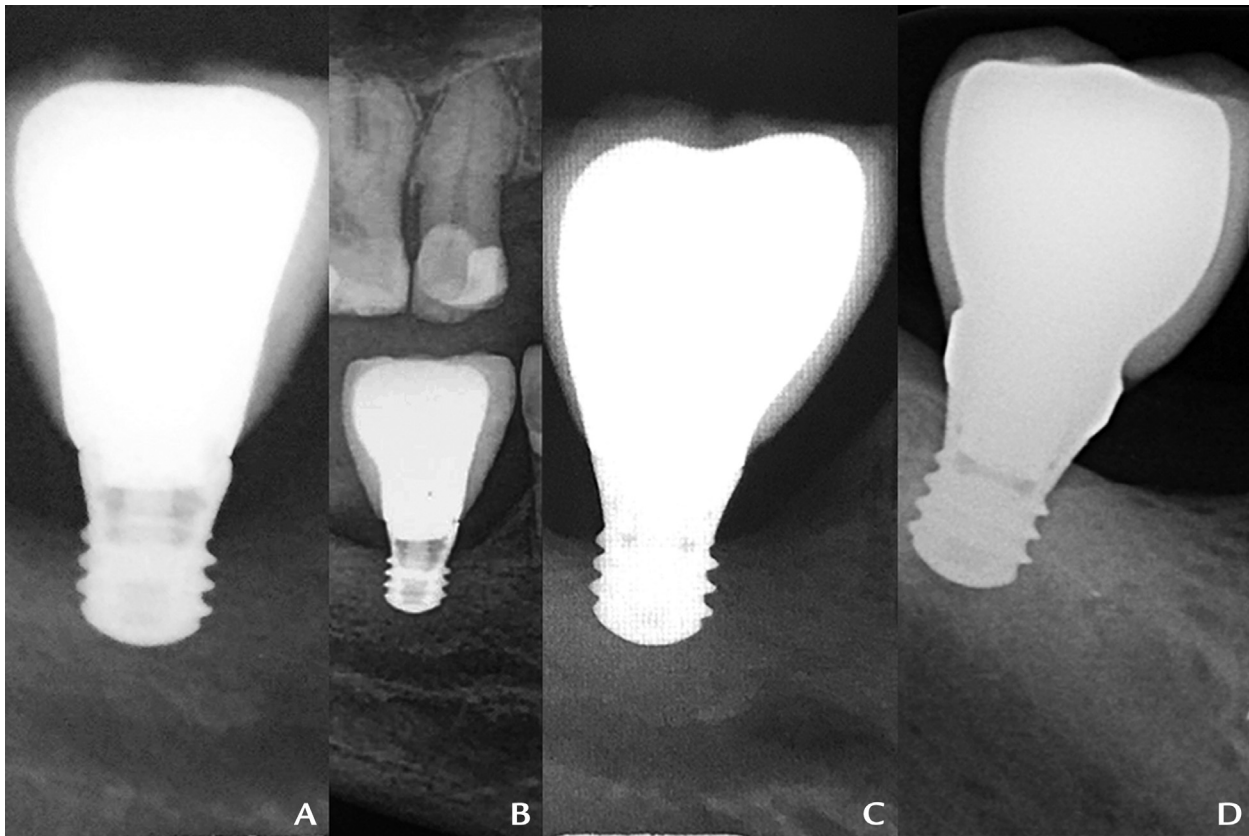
Radiographs at follow-up visits. A, 1 year. B, 2 years. C, D, 3 years
